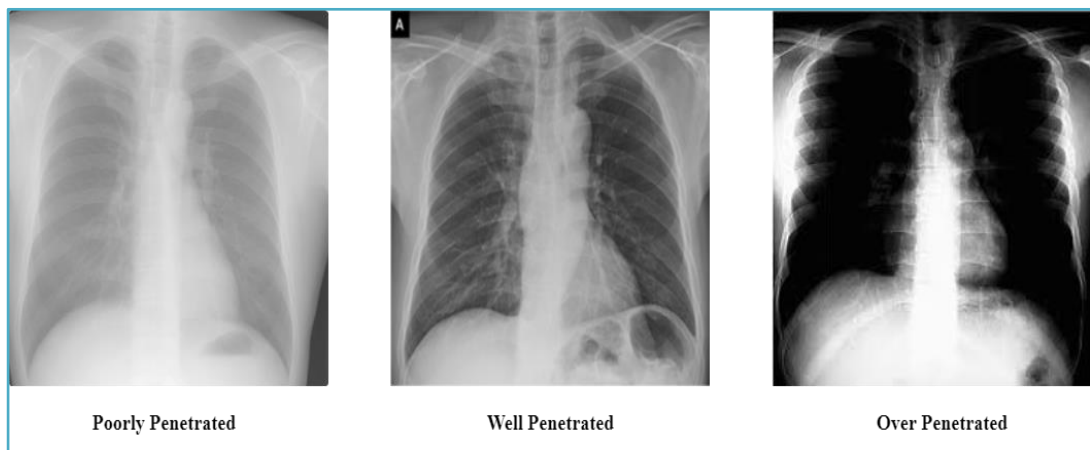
The view of poorly, well and over penetrated Chest X-Ray Images[28].
